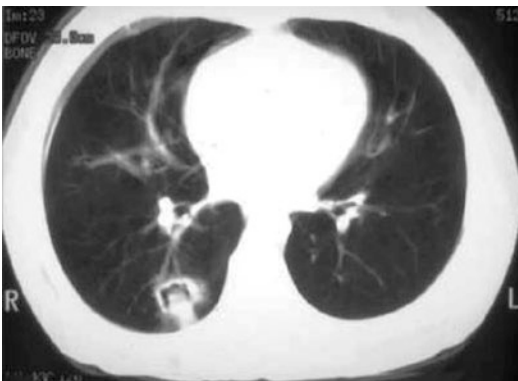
Aspergillosis. “Half-moon” shaped, cavitated nodular opacity in an axial section of a CT scan, due to *Aspergillus* infection in a child with acute lymphoblastic leukemia
